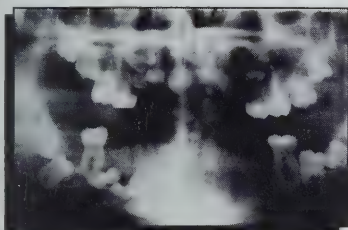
Radiographie panoramique prise deux mois en post-opératoire démontrant le site chirurgical en voie de guérison et les dents laissées en place.
